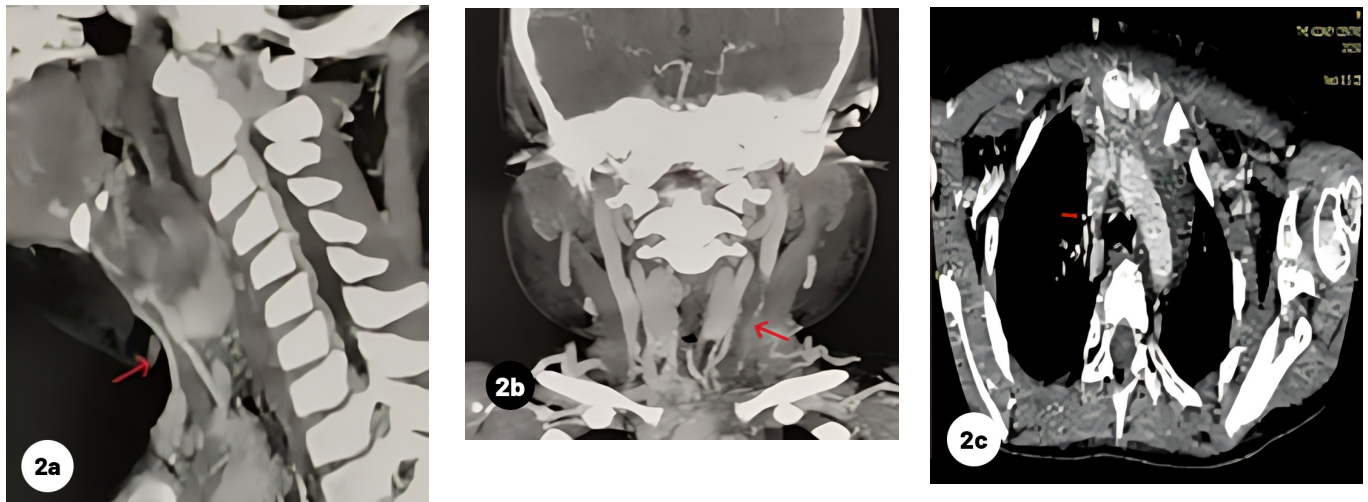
Sagittal and Fig. 2b: Coronal contrast enhanced CT images, showing a well-organized hypodense thrombus within the internal jugular vein on left side, resulting in near total luminal occlusion, Fig. 2c: Axial contrast enhanced CT image, showing organized hypodense thrombus in SVC.
